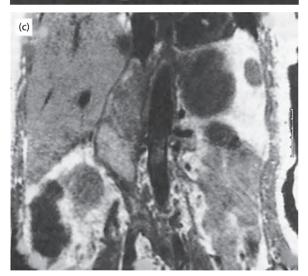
(a) MRI scan of a patient with a massive left adrenocortical carcinoma. (b) CT scan showing the tumour within the lumen of the inferior vena cava (IVC). (c) MRI scan showing tumour invasion of the IVC.
